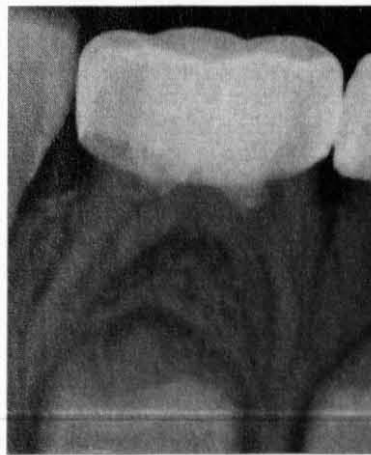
Eleven months post-op, a periapical radiograph showed continued stability and furcation bone healing.
